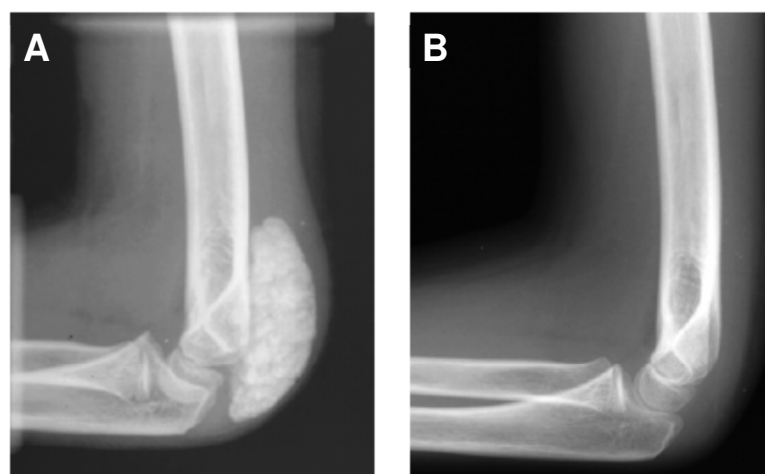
Characteristic findings of FTC in a 12-year-old boy. Calcinosis usually occurs in and just under skin tissue around the joints, most often the hips, shoulders and elbows. Radiographs show the left elbow (A) before and (B) after resection of a discoid lobulated calcified tumour-like (tumoural) mass in the soft tissue of the extensor site of the left distal humerus (Benet-Pages et al., 2005).
